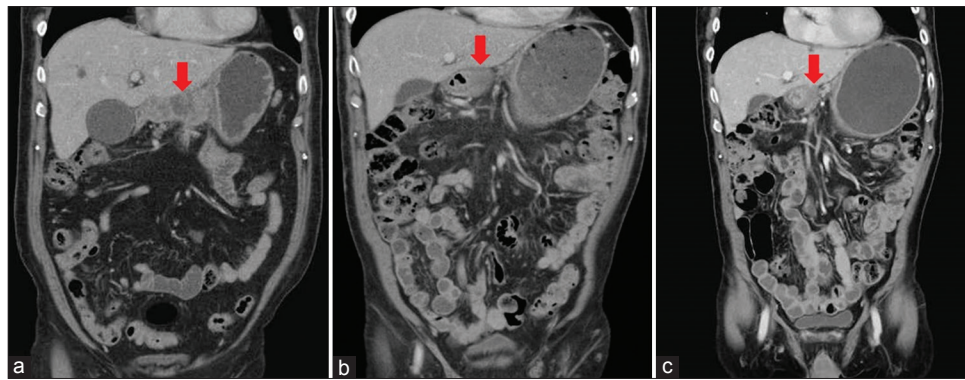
(a) Coronal image of an abdominal CT scan from April 2020 revealing an irregular wall thickening at the gastric antrum. (b) Coronal image of an abdominal CT scan from July 2020 revealing a regressive change in the irregular wall thickening at the gastric antrum. (c) Coronal image of an abdominal CT scan from April 2021 revealing a stable condition in the irregular wall thickening at the gastric antrum. CT: Computed tomography
